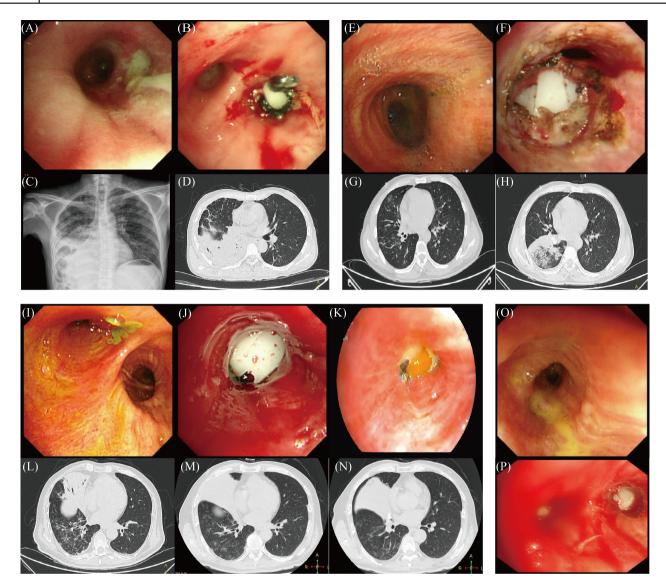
(A)–(D) is the imaging data of patient 1. (A) Bronchoscopy revealed that the pus mainly came from the basal segment of the right lower lobe and the dorsal segment of the right lower lung. (B) Use 2 self-made silicone plugs to block the basal segment of the right lower lobe bronchus (B6–B10). (C) x-ray shows incomplete expansion of the patient's right lower lung with pleural effusion before operation. (D) Postoperative CT showed the position of the metal stent. (E)–(H) is the imaging data of patient 2. (E) Bronchoscopy showed that the yellow green secretion mainly came from the distal end of the right lower lobe outer basal segment of the bronchus (B9). (F) Insert a silicone plug into the proximal end of the right lower lobe posterior basal segment bronchus (B10) and completely block the right lower lobe anterior, lateral, and posterior common trunk bronchus (B8–B10). Finally, burn with an argon knife (40 W). (G)–(H) Comparison of preoperative (left) and postoperative (right) CT shows that the silicone plugs successfully occluded the target bronchus. (I)–(N) is the imaging data of patient 3. (I) Bronchoscopy revealed fresh bile overflow in the medial segment of the right middle lobe bronchus (B5). (J) An 8 * 8 * 10 mm silicone plug was inserted to block the target bronchus in the right middle lobe. (K) Two months later, the bronchoscopy revealed that the silicone plug was successfully sealed, showing a light-yellow colour and no surrounding secretions overflowing. (L)–(N) CT showed inflammation in the lower lobe of the patient's right lung (left), with improvement after SBO (middle). Silicone plug was used to occluded the target bronchus (B8) and the right lower lobe posterior basal segment bronchus (B10). And two silicone plugs were inserted after SB.
